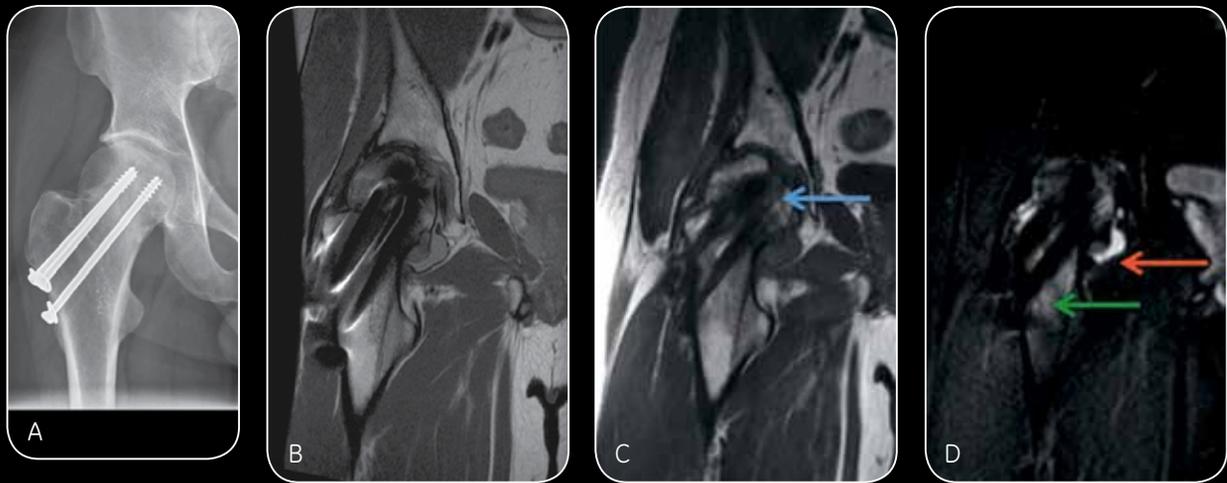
Radiograph (A), MARS (B), and MAVRIC SL (C-D) images of fixation screws at 1.5T. The use of MAVRIC SL clearly visualizes necrosis (blue arrow) in the T1w image (C), along with fluid buildup (red arrow) and widespread edema (green arrow) in the STIR image (D).
